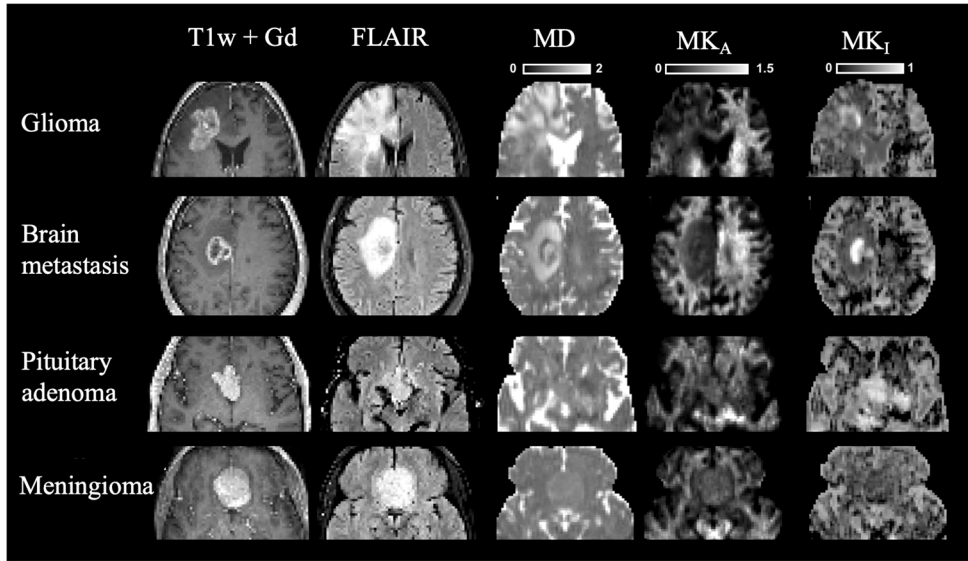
MRI parameter maps in different intracranial tumor types. Both the glioblastoma and brain metastasis cases exhibited low MK_A , whereas the pituitary adenoma and the meningioma cases exhibited higher MK_A . All tumors in this figure, except the meningioma, displayed regions with markedly elevated MK_I . Figure adapted from Paper IV, published by Wiley and licensed under CC BY-NC 4.0.
